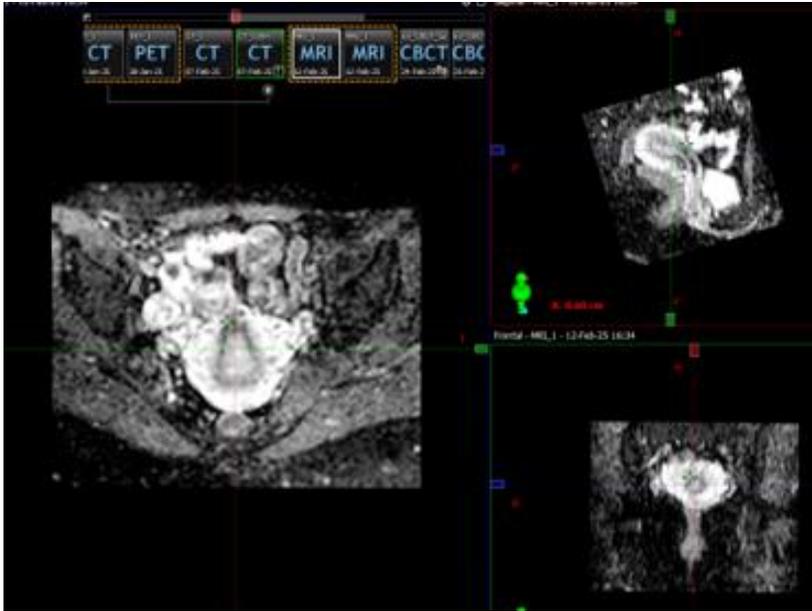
MRI of the uterine body with: a few small uterine myomas.
